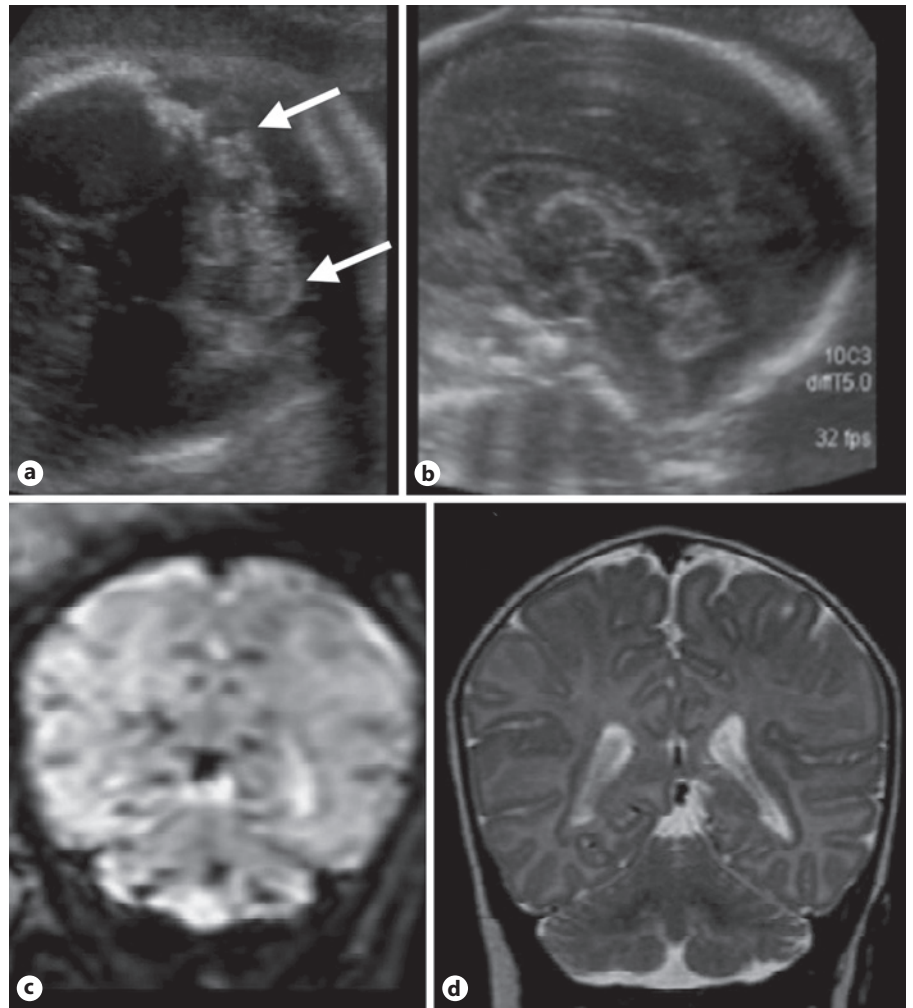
Case 6. Bilateral cerebellar hemorrhage with a normal vermis and biometry. a, b Ultrasound at 23 weeks of gestation. a Axial view at the level of the cerebellum showing bilaterally increased echogenicity of the lateral parts of both cerebellar hemispheres (arrows). b Midline sagittal slice showing a normal vermis. c MRI at 32 weeks of gestation. Gradient echo T2-weighted coronal slice showing a marked hypointensity signal in the inferolateral part of both cerebellar hemispheres. d Postnatal MRI at 3 months of age. T2-weighted coronal slice showing a slight irregularity of the inferior border of the cerebellar hemispheres.
